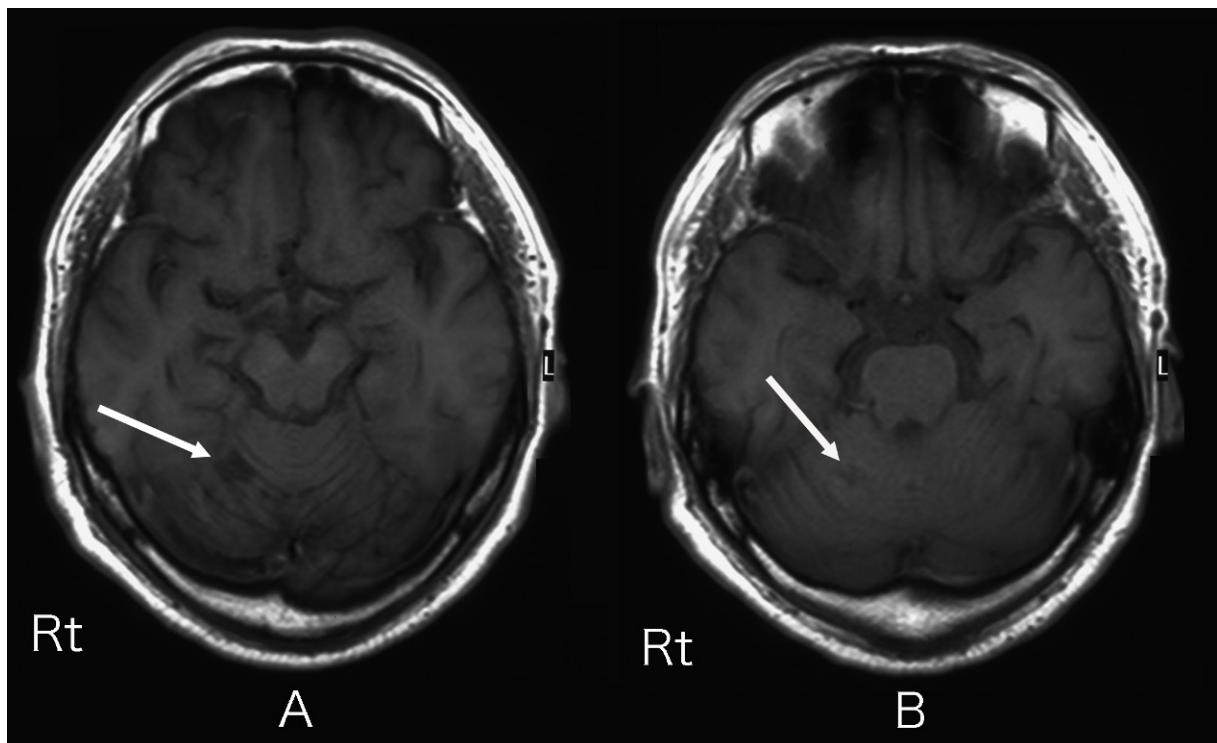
T1-weighted cranial MRI (TR 631 msec / TE 13 msec). An infarct was located in the lobulus simplex (A) and lobulus semilunaris superior (B) of the upper cerebellar hemisphere on the right side. Paravermal zone was involved in the infarct.
